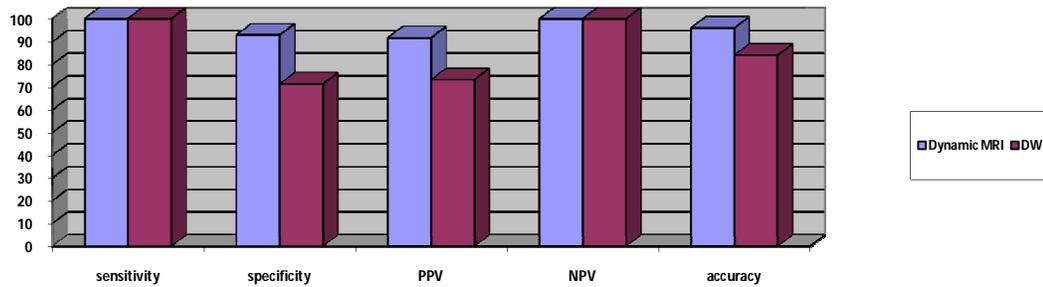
The different indices of the Dynamic MRI and DWI in post-RFA lesions.
